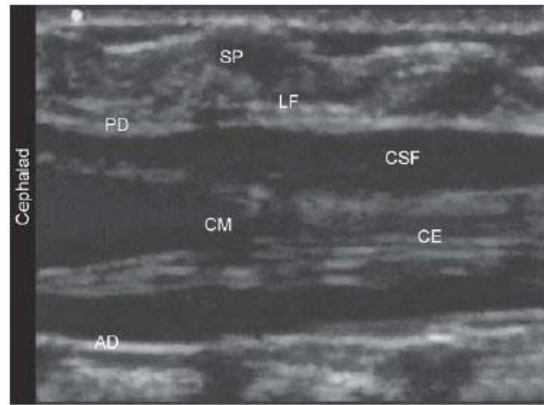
ultrasound image showing lumbar Sonoanatomy. CM-Conus medullaris, CE – Cauda equina, CSF – Cerebrospinal fluid, PD - Posterior dura, AD – Anterior dura, SP – spine
